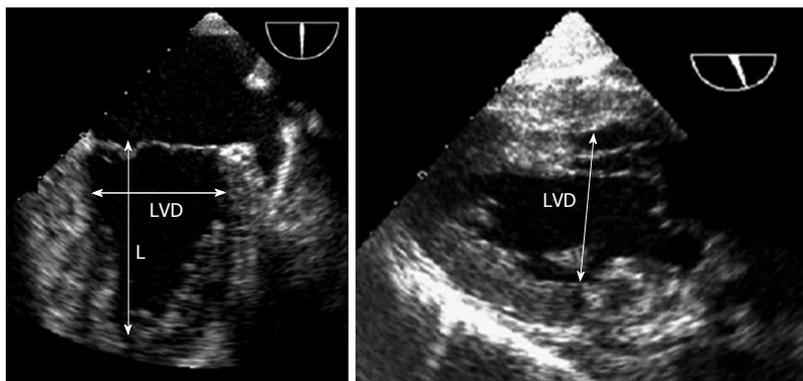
Transoesophageal measurements of left ventricular length and minor left ventricular diameter from the ME 2C, usually best imaged at a multiplane angle of approximately 60°-90° and from the trans-gastric two-chamber view of the left ventricle, usually best imaged at an angle of approximately 90°-110°. L: Length; LVD: Left ventricular diameter.
